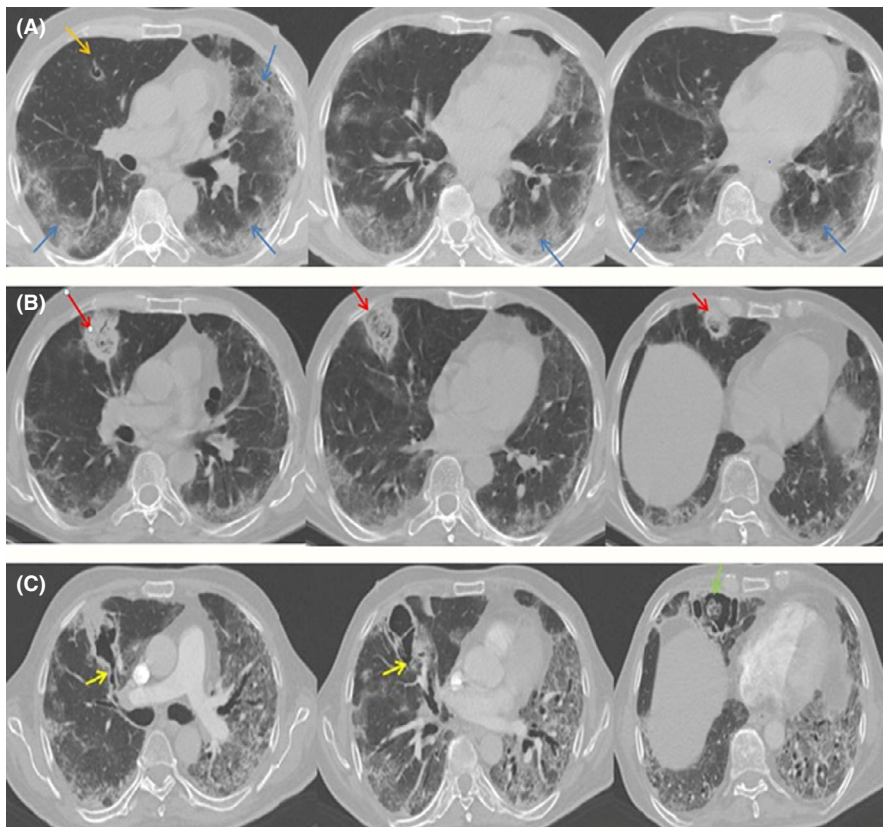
A, Contrast-enhanced computed tomography chest showing multi-lobar peripheral ground-glass opacities; B, the reduced ground-glass opacities and three new foci of peripheral wedge-shaped air-space opacities with reverse halo developed in the right middle lobe; C, the yellow arrows depict the foci of bronchial wall defects. The green arrow shows sloughed debris mimicking invasive aspergillosis
